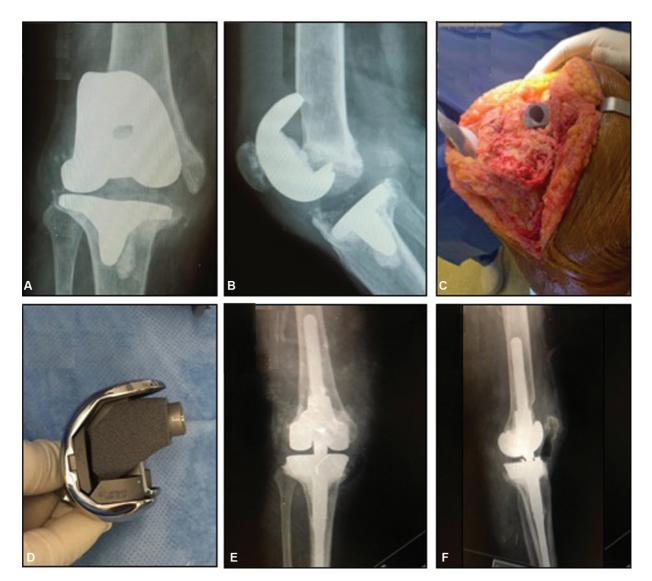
(A) and (B) Preoperative radiographs of aseptic total knee arthroplasty failure with severe distal femoral defect; (C) metaphyseal tantalum cone positioned to treat bone defect; (D) Profile image of the definitive femoral component plus a tantalum cone and distal and posterior femoral wedges; (E) and (F) Postoperative radiographs.
